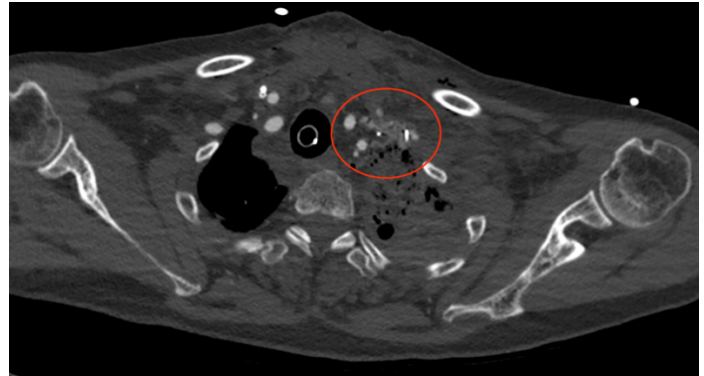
Computed Tomography Angiography of hematoma and hemorrhagic infarction of tissues of the supraclavicular fossa after subclavian artery lesion.
